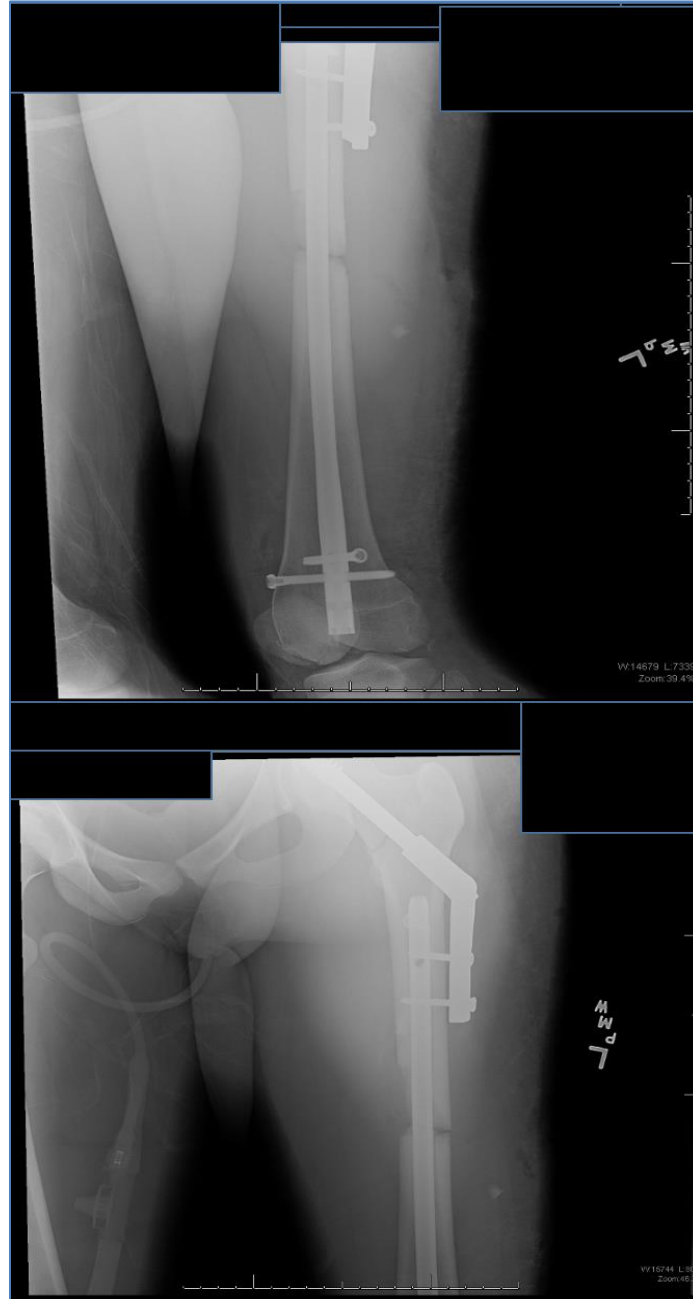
Post-operative A/P radiographs following surgical fixation of ipsilateral femoral neck and shaft fracture. Top image demonstrates distal femur with proper alignment and fixation of retrograde femoral nail. Bottom image demonstrates proximal femur with proper fixation and alignment of sliding hip screw.
